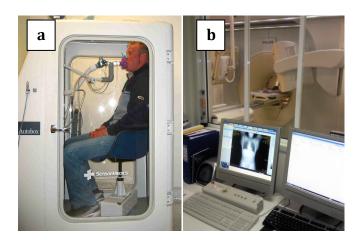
Lung volume measurements using plethysmography (a.) and computed tomography (b.) in a healthy freediver.
